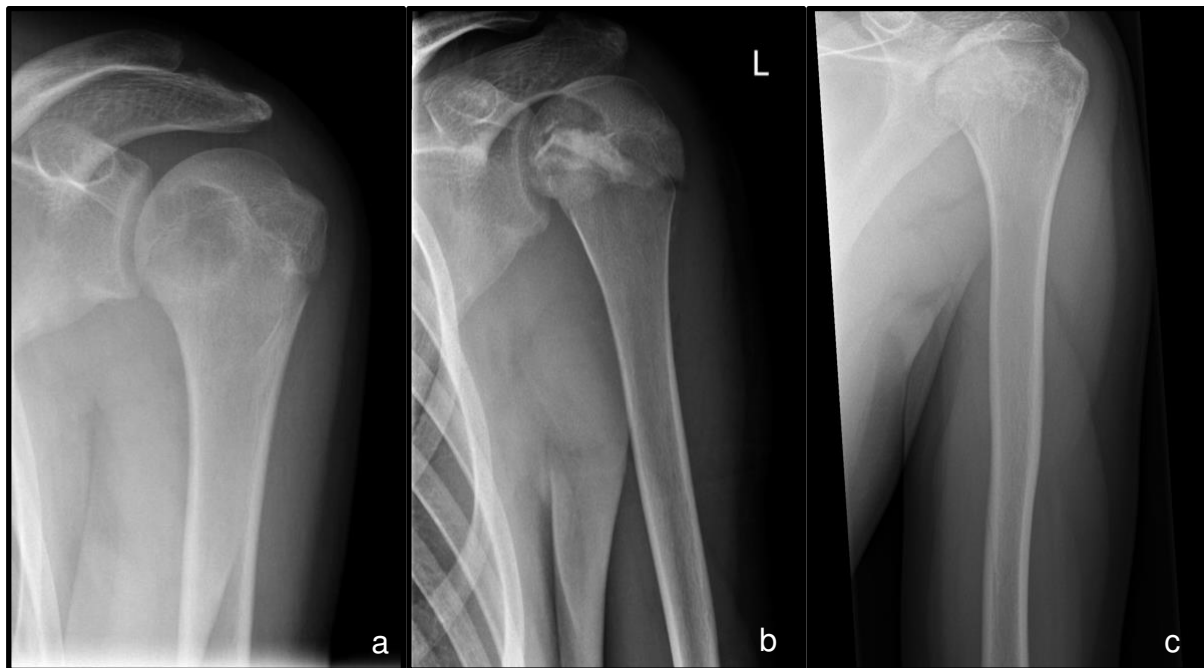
(17a) Postoperative x-ray of a 21-year-old male patient one day after curettage and filling of an enchondroma in the left humeral diaphysis, and (17b) after a pathologic fracture within the curretted area that occurred after minor trauma five weeks after primary surgery. (17c) Follow-up radiograph following plate osteosynthesis in order to stabilize the pathologic fracture five weeks after primary surgery, with the kind permission of Springer Nature, according to figures 5a, 5b and 5c in "Artificial bone graft substitutes for curettage of benign and low-grade malignant bone tumors: clinical and radiological experience with Cerasorb", Indian Journal of Orthopaedics, published online on June 22nd, 2023 (1).
